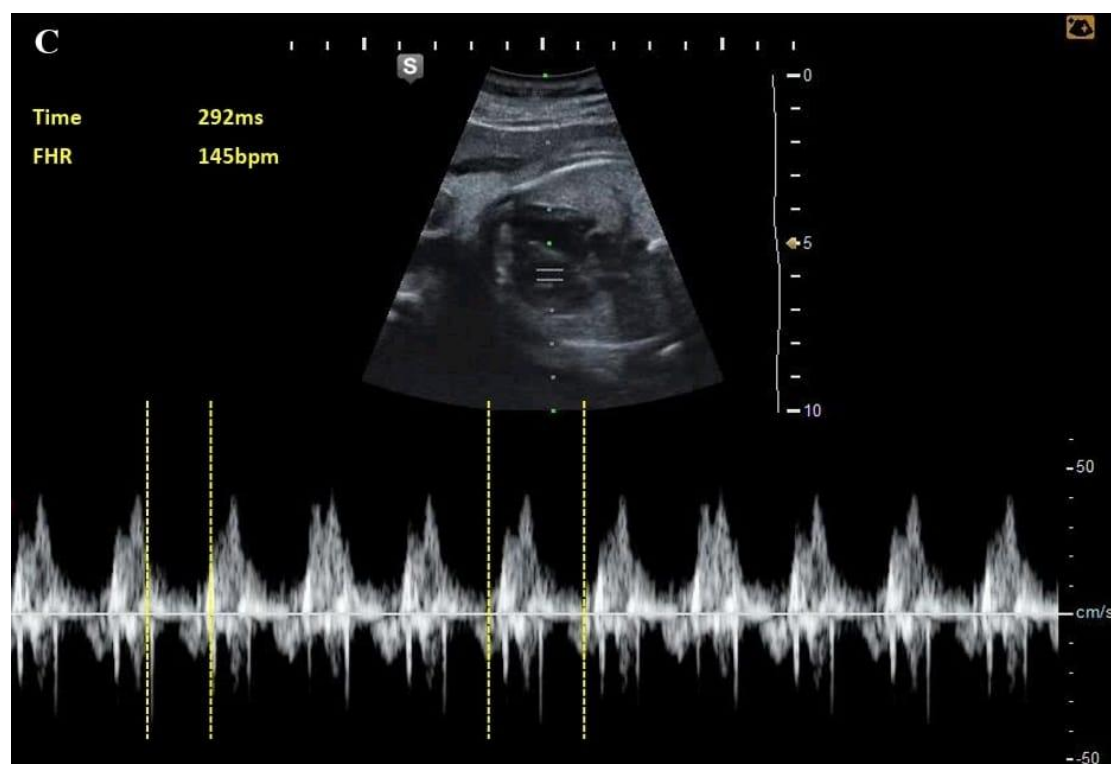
Measurement of right ventricular (MPI) using pulsed wave Doppler just below the PV(b)time interval between the aperture and the closure of the pulmonary valve was measured in (B) and at the tip of TV leaflets (a) time interval from closure to aperture click of the tricuspid valve was measured in (C) and then MPI was calculated with following way (a-b)/b, so Tei index of RV (292-180)/180=0.62 with fetal heart rate 143-145 bpm.
